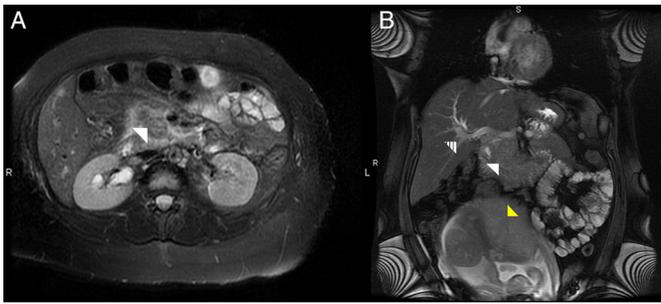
T2-Weighted abdominal magnetic resonance imaging from initial presentation at 26 weeks. (A) Axial view showing a space-occupying lesion in the head of the pancreas (arrow) with ill-defined margins and involvement of the superior mesenteric vein. (B) Coronal view demonstrating a pancreatic head lesion (white arrow) and surrounding edema with mild dilatation of the CBD (striped arrow) and visualization of gravid uterus (yellow arrow).
